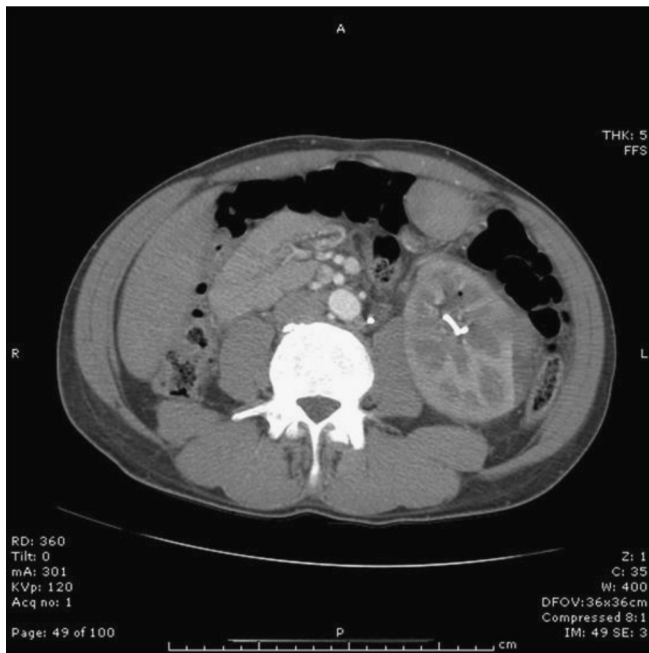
Computed tomography scan (October 11, 2013) showing fluid in the left collecting system with no obvious mass or stone.
